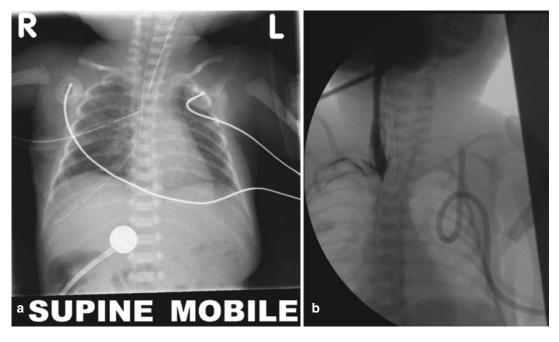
(a, b) Iatrogenic esophageal perforation. (a) Frontal chest radiograph showing abnormal course of the orogastric tube terminating in the right upper abdominal
